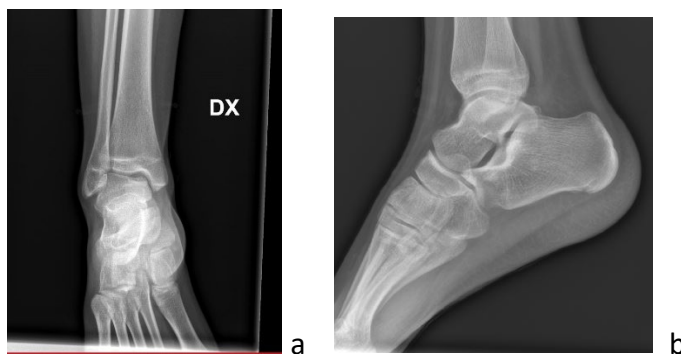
Non-weight-bearing foot X-rays . 33-a anterior view, 32-b posterior view
